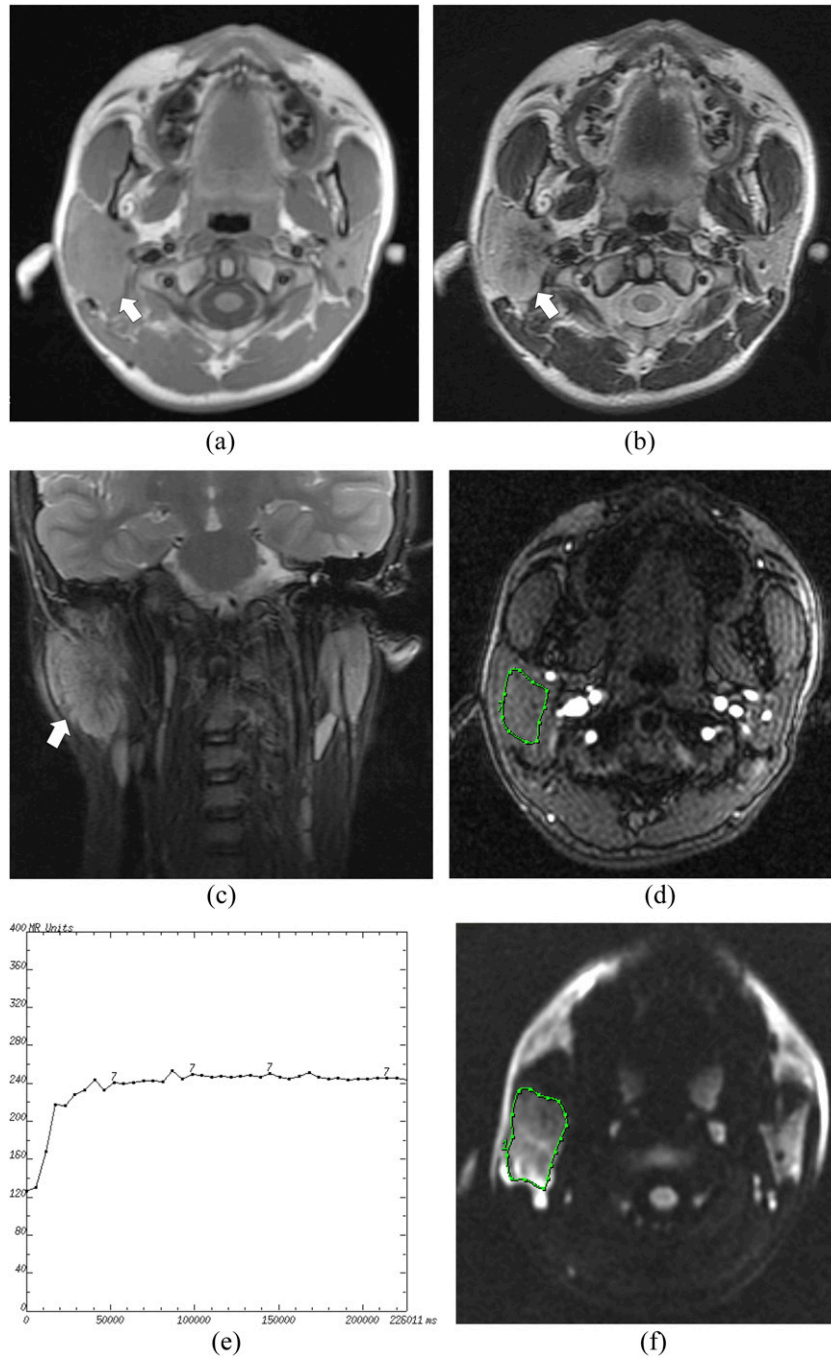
A Warthin's tumour of the right parotid gland in a 48-year-old male: (a) the axial  $T_1$  weighted MR image shows an isointense signal mass with a round shape (arrow) in the right parotid gland. (b) The axial  $T_2$  weighted MR image shows a relatively hyperintense mass (arrow). (c) The coronal  $T_2$  weighted MR image shows a hypointense capsule around the mass (arrow). (d) The round cursor marks the region of interest (ROI) selected for the signal intensity (SI) measurement with dynamic MRI. (e) The time-intensity curve shows a washout enhancement pattern (Type B). (f) The diffusion-weighted image shows a high SI mass. The round cursor marks the ROI selected for measurement of the apparent diffusion coefficient (ADC) value. The mean ADC value of this tumour is measured as  $0.74 \times 10^{-3} \text{ mm}^2 \text{ s}^{-1}$ .
